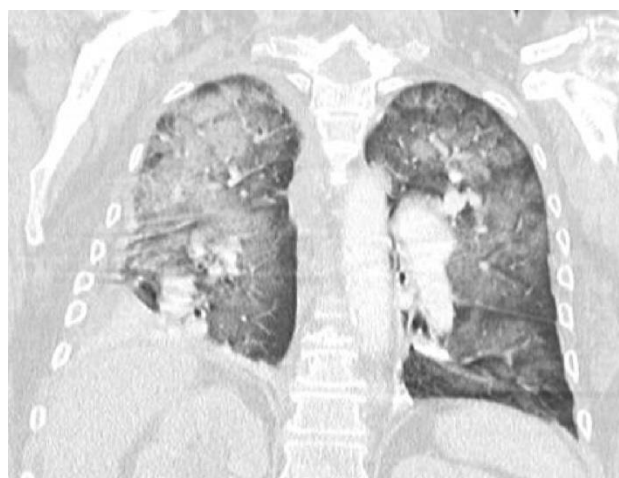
HRCT chest coronal reformatted image shows ground glass opacity with interlobular septal thickening in bilateral lung fields predominantly on right side.
